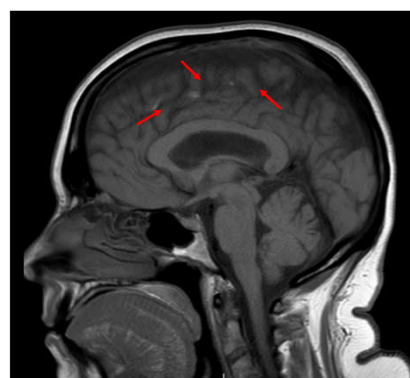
Multiple foci of infarction on MRI in frontal, parietal and temporal cortex.
